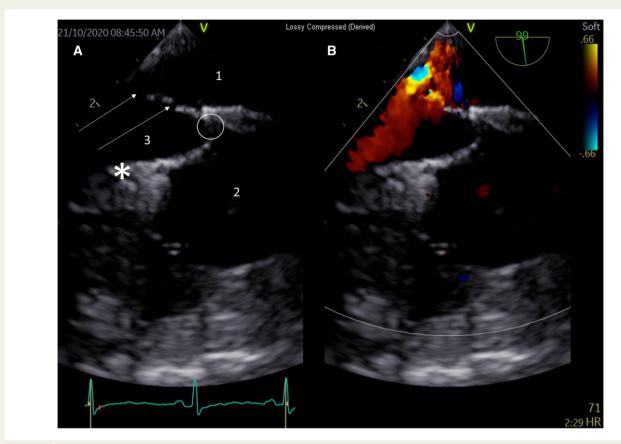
Transoesophageal echocardiography image in a projection of the caval axis. The colour flow comparison between the two-dimensional image (*A*) and its corresponding colour flow Doppler image (*B*) is represented by the left and right images, respectively. The imaging reveals a right-to-left shunt flow from the inferior vena cava to the left atrium through multiple fenestrations connected to the inferior vena cava at the interatrial septum. The inferior margin of the surgically placed interatrial patch was shifted to the right, excluding the inferior vena cava orifice from the right atrium (1 = left atrium; 2 = right atrium; 3 = inferior vena cava; arrows = multiple fenestrations; asterisk = inferior margin of the incorrectly positioned surgical patch).
